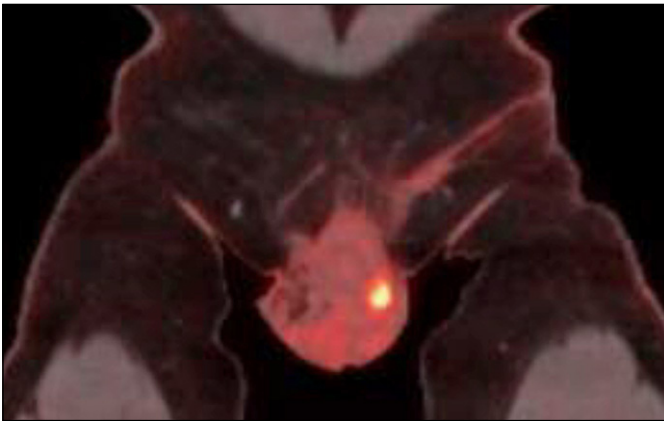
Coronal section of scrotum on PET-CT, FDG-avid hotspot after surgery.
